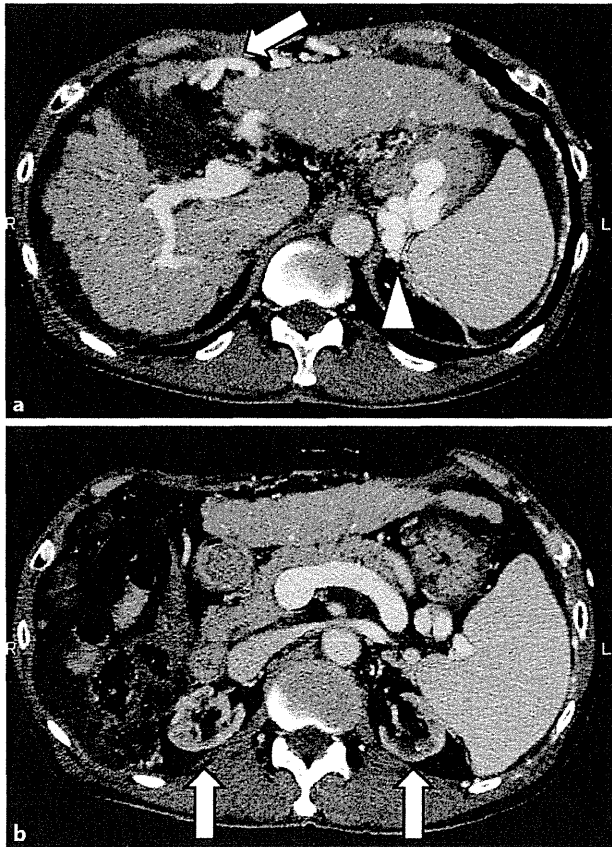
Pretransplant computed tomography scan. a The liver was cirrhotic and had no definite hepatocellular carcinomas. Moderate ascites, recanalized paraumbilical vein (arrow), gastric varices (arrowhead) and splenomegaly were identified. b The bilateral kidneys were very atrophic (arrows).
